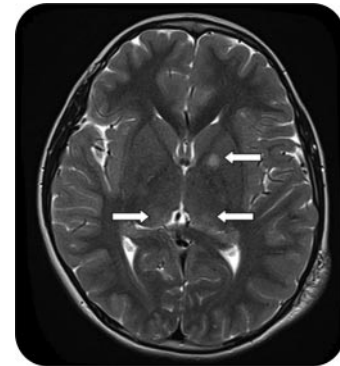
MRI brain (coronal T2-weighted)
